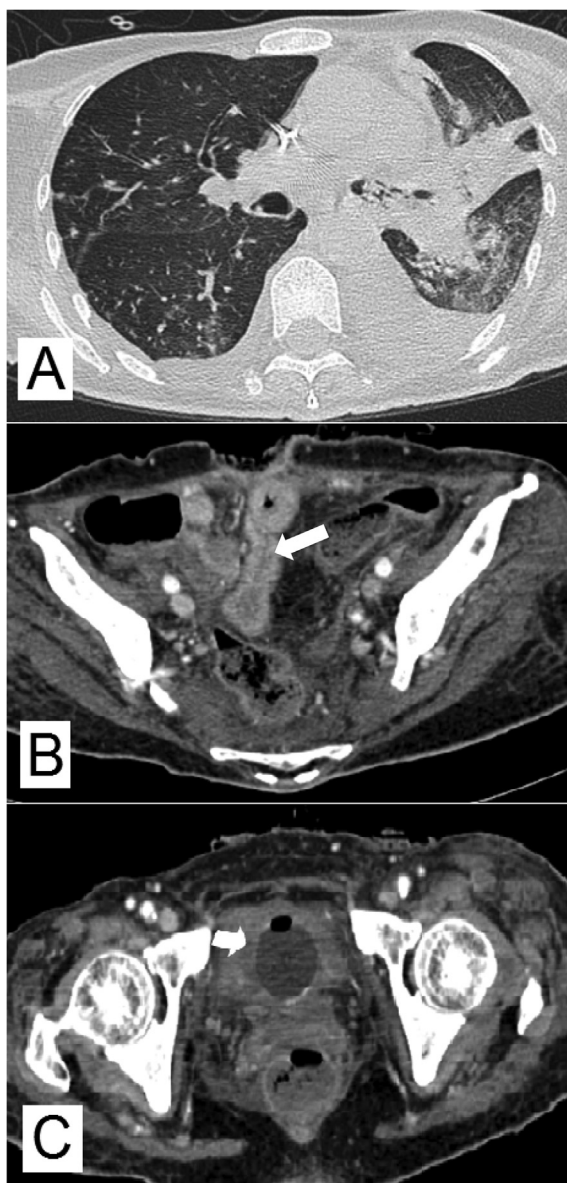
High resolution computed tomography of the chest axial view showing left upper lobe collapse, bilateral pleural effusion, and ground glass opacity with peripheral fibrosis (A). Contrast enhanced computed tomography of the abdomen showing hyperdense and thickened small intestines wall (arrow) (B) and bladder wall is diffusely thickened (arrow) (C).
